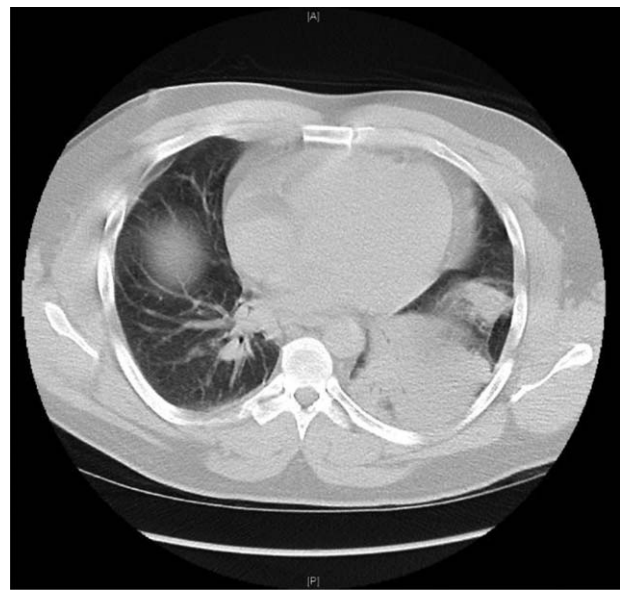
CT chest from prior hospital admission showing left lower lobe infiltrate.
